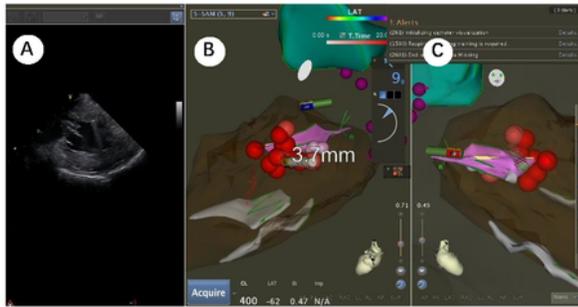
A: intracardial echocardiography showed the ablation area. Three-dimensional electroanatomical map of the left ventricular outflow tract (LVOT) endocardial surface created by the electroanatomical CARTO mapping system (CARTO 3 system, Biosense Webster). Pink dots: subaortic septal regions in which branching of the conduction system was detected; Red dots: sites of radiofrequency ablation. The area of ERASH reaching 1.6cm<sup>2</sup>. B: LAO view. C: RAO view.
